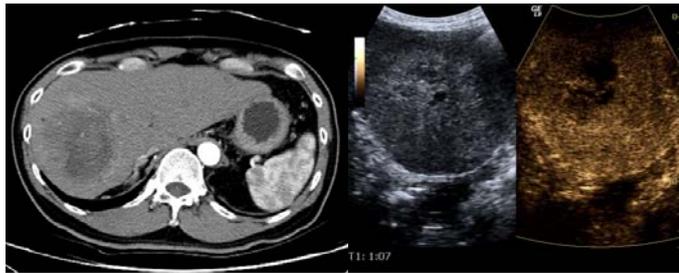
Comparison of a Hepatocellular carcinoma (HCC) liver lesion as seen in CT (left*) and CEUS (right).
